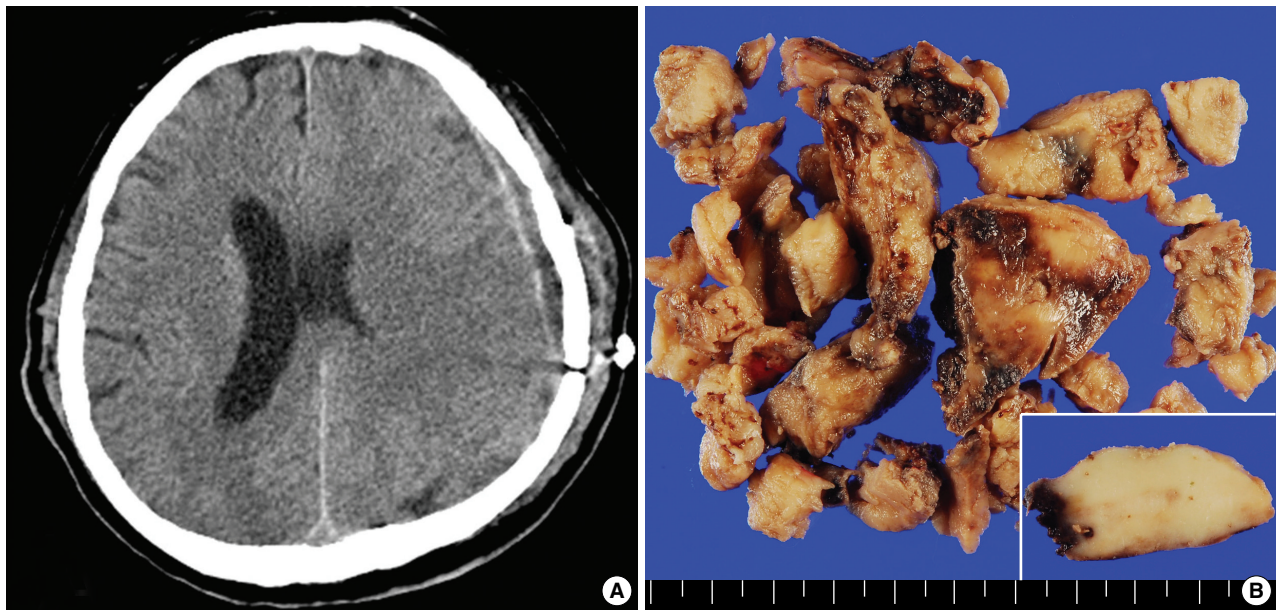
CT scan of the head shows a crescent-shape enhancement in the left fronto-temporo-parietal area, and deviation of the left ventricle to the right side due to diffuse brain edema (A). The tumor masses submitted in fragments are gray white and firm (B).
